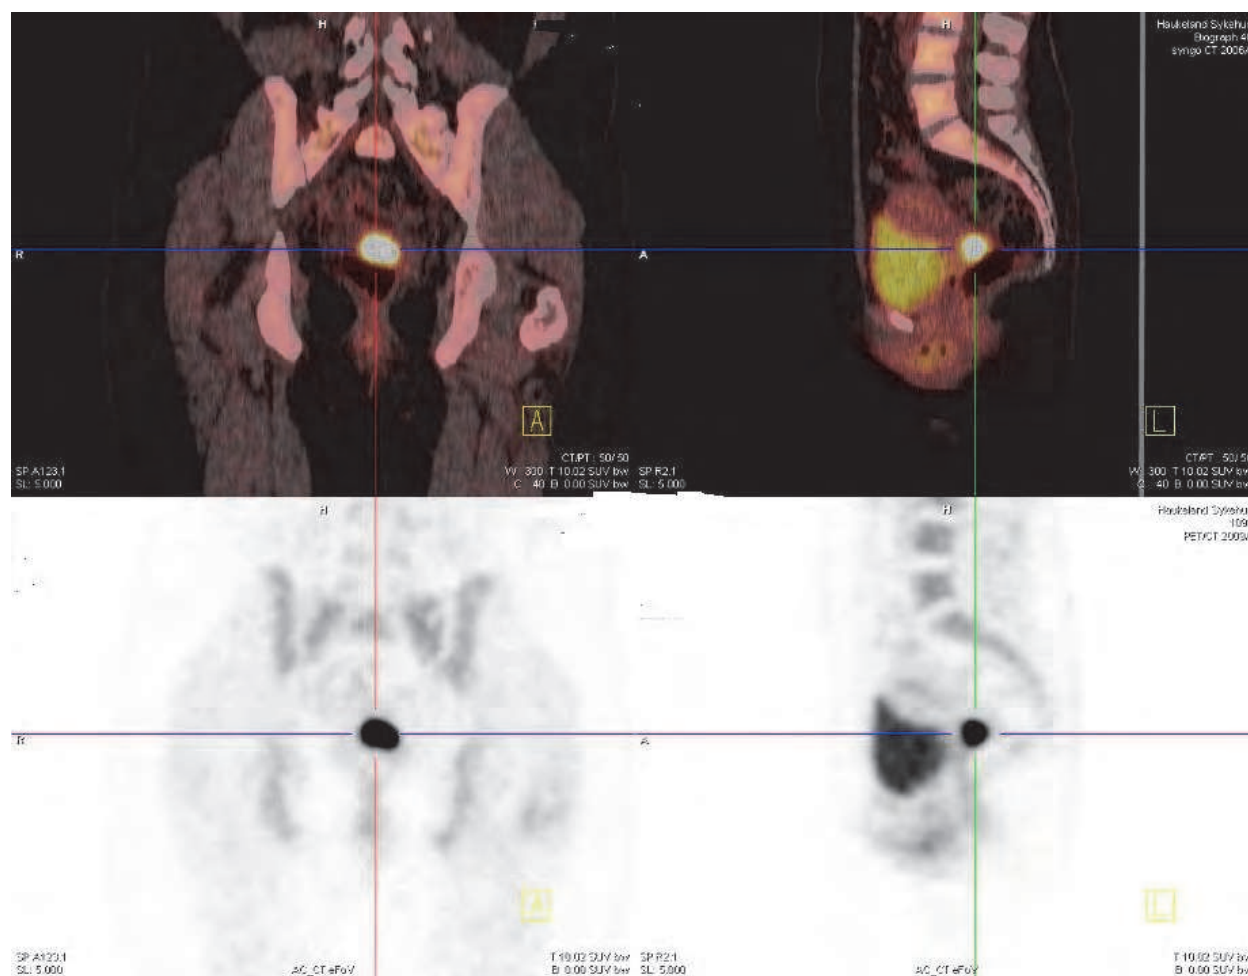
PET/CT and MRI of a localised uterine cervix NEC before initiation of neoadjuvant chemotherapy.
